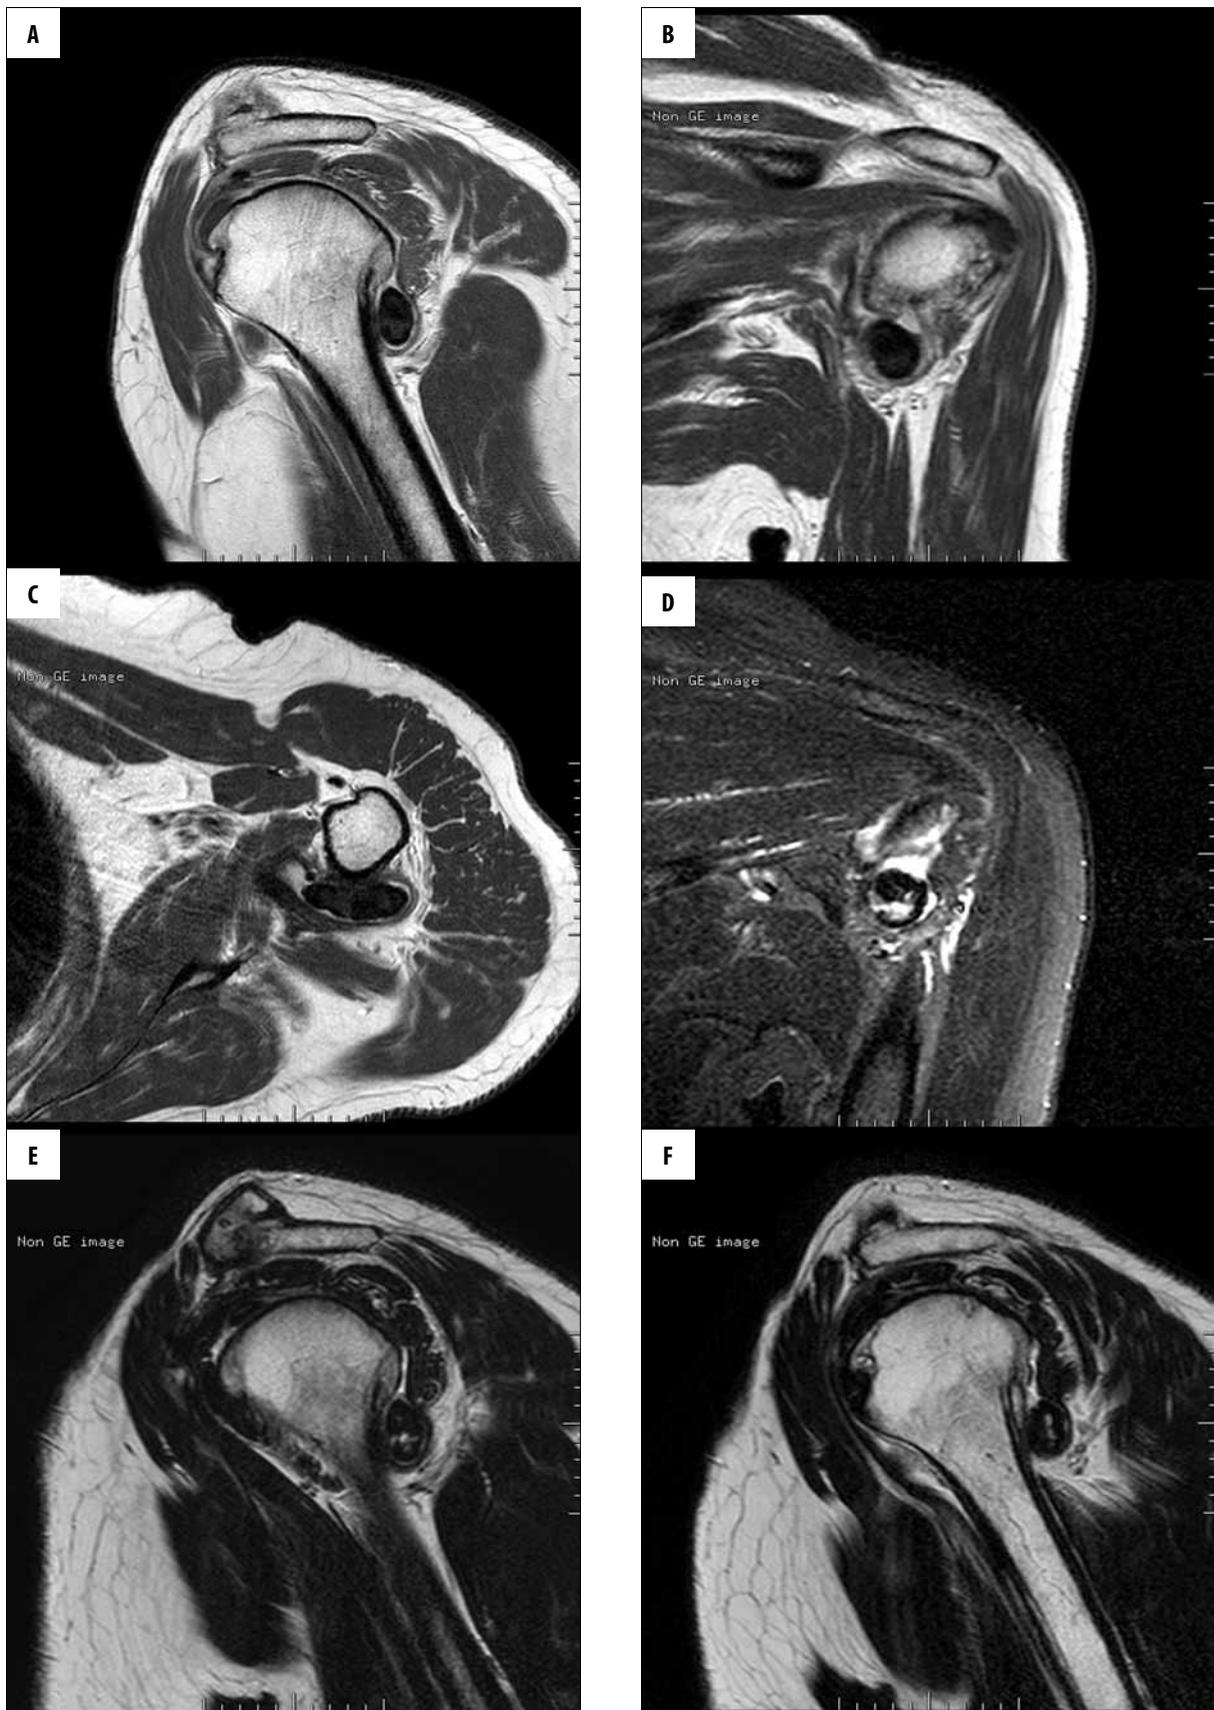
Shoulder MRI. T1-weighted images + CM: (A) Sagittal plane. (B) Frontal plane. (C) Transverse plane. T2-weighted images: (D) Frontal plane. (E, F) Sagittal plane. Synovial chondromatosis in the axillary recess of glenohumeral joint.
